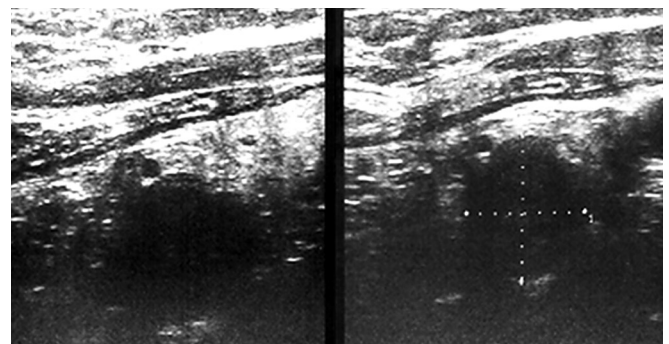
Ultrasound examination showing a solid, homogeneous and hypoechoic tumour (white dotted cross)
